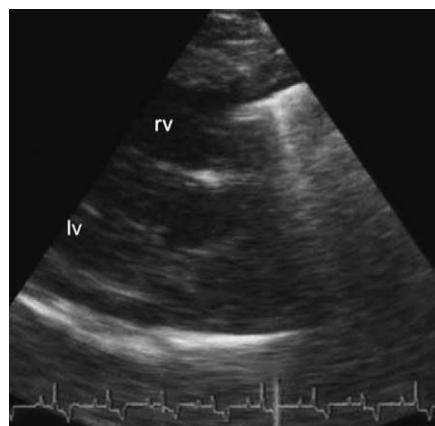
Echocardiographic picture, right parasternal location, longitudinal axis, four-chamber inflow view. Hyperechoic structure in the area of the tricuspid valve with distal reverberations. rv Right ventricle, lv Left ventricle
